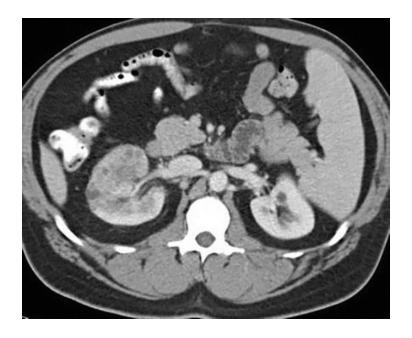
Contrast-enhanced CT demonstrates an infiltrative right urothelial cell carcinoma
